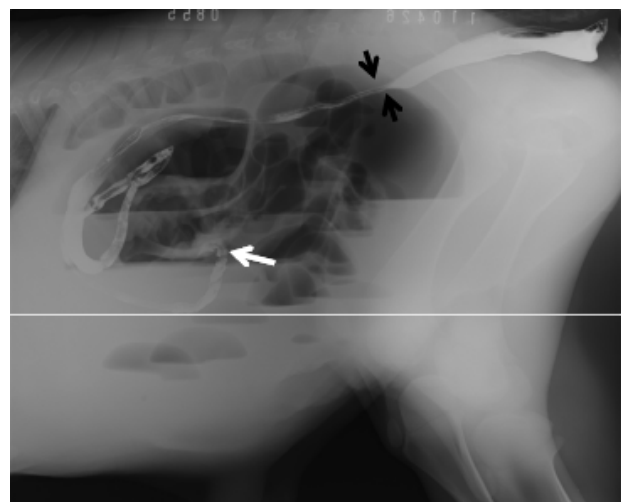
Contrast radiograph revealing the presence of stenosis at the junction between the colon and rectum (black arrows) and barium sulphate which was passed through a narrow canal and was then blocked at a blind sac (white arrow)
